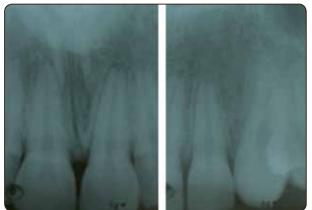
Periapical radiograph showing root resorption at the apices of central and lateral incisors following orthodontic treatment.
